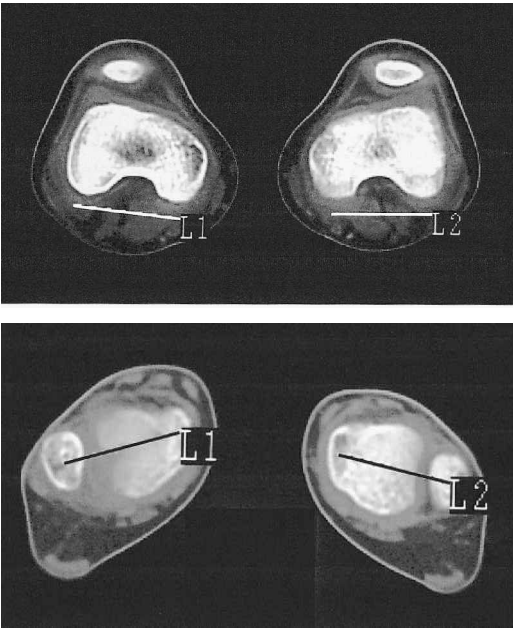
Computed tomography for measuring tibial torsion. The proximal reference line is determined as the dorsal tangent to the femoral condyles. The distal reference line is measured from the center of the medial malleolus to the center of the lateral malleolus. Tibial torsion is measured as the angle between the two lines.
